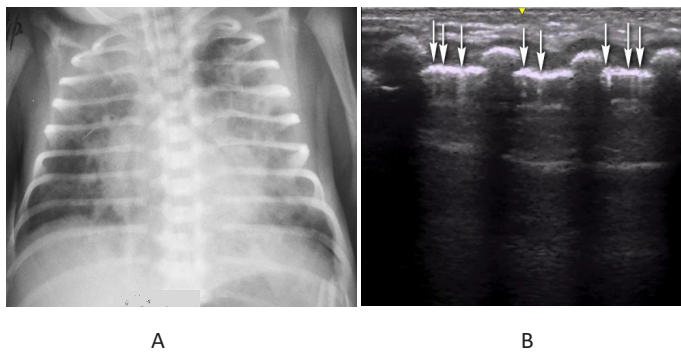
Newborn, gestational age 29 weeks. Respiratory distress syndrome of III degree. A. X-ray reveals an inhomogeneous decrease in the transparency of the pulmonary fields with the presence of an “air bronchogram”. B. An ultrasound reveals 3 B-lines in one intercostal space.
